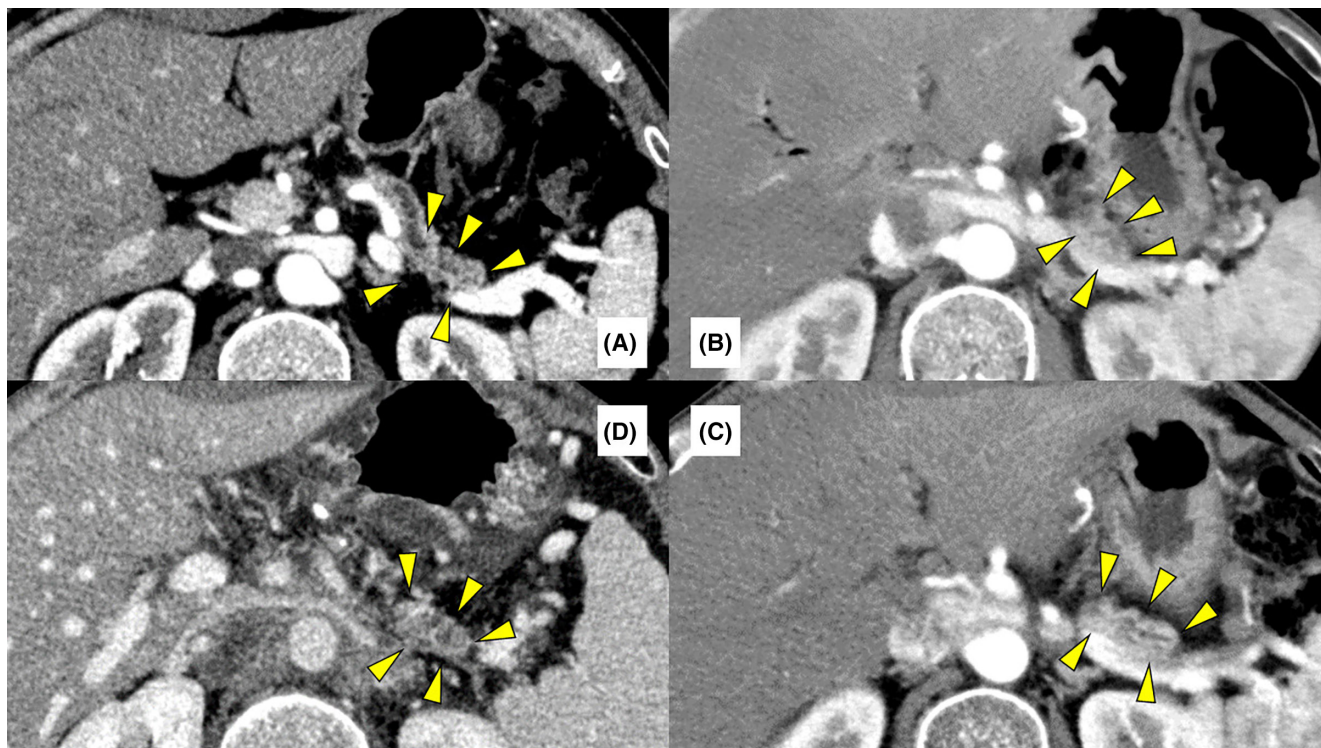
CT findings of the remnant pancreas in the representative case. There was no aggravation of MPD dilation in the 3 years following pancreatectomy. (Arrow heads: remnant pancreas) (A) Preoperative findings. (B) One year after pancreatectomy. (C) Two years after pancreatectomy. (D) Three years after pancreatectomy.
